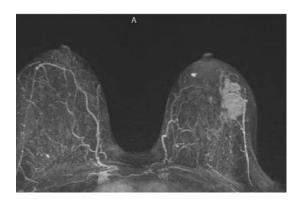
Contrast enhanced breast MRI with 3 dimensional reconstruction revealed lobulated enhancing mass in the left breast
